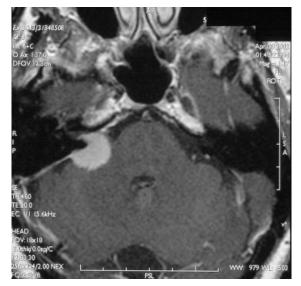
Meningioma. A 52-year-old woman complained of tinnitus and right-sided hearing loss for 6 months. Enhanced axial T1-weighted MRI of the posterior fossa shows a $16 - \times 11 - \times 18$ -mm large, heterogeneous, sessile lesion. The lesion extended into the internal auditory canal, but did not widen it.
